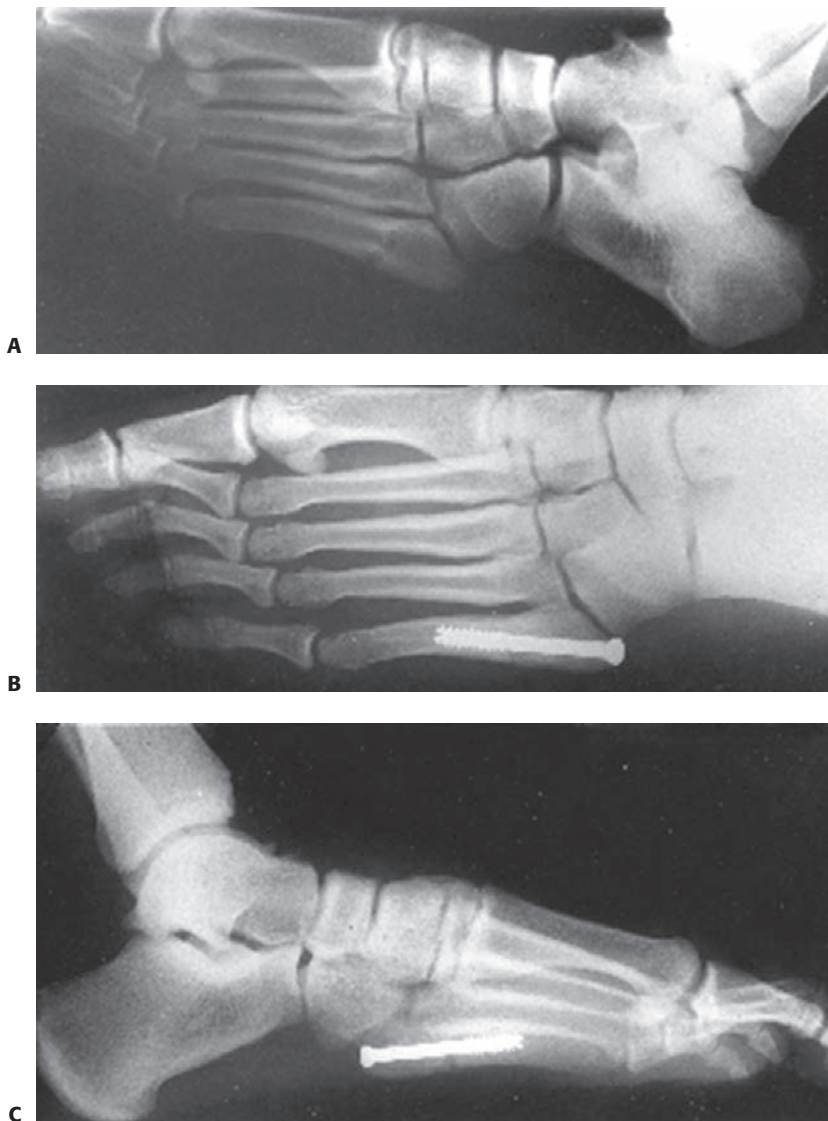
This 15-year-old high-level basketball player sustained a proximal fifth metatarsal fracture at the metaphyseal–diaphyseal junction. The patient chose intramedullary screw fixation because of his desire to return to sport as promptly as possible, lessen his time in immobilization, and lessen the risk of delayed union or nonunion. A: Radiograph at time of injury. B, C: After intramedullary screw fixation. (Courtesy of Keith S. Hechtman, MD.)
